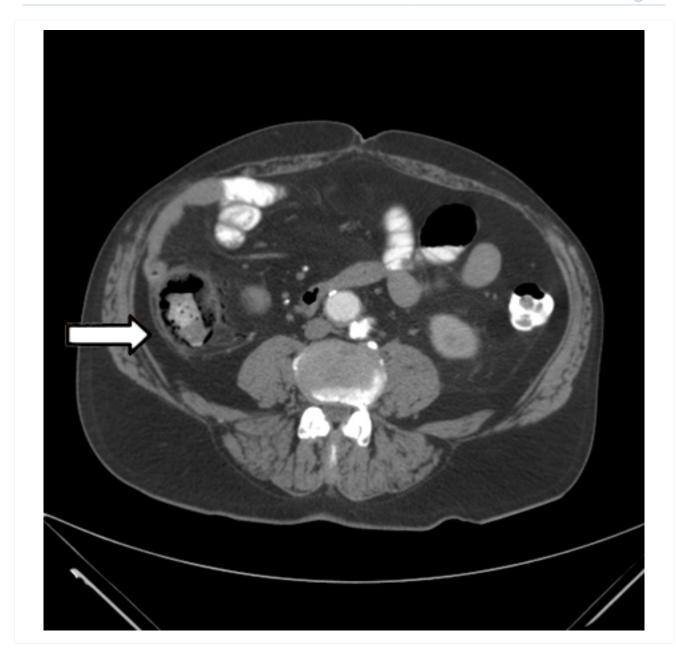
CT scan: colonic thickening with pneumatosis intestinalis
